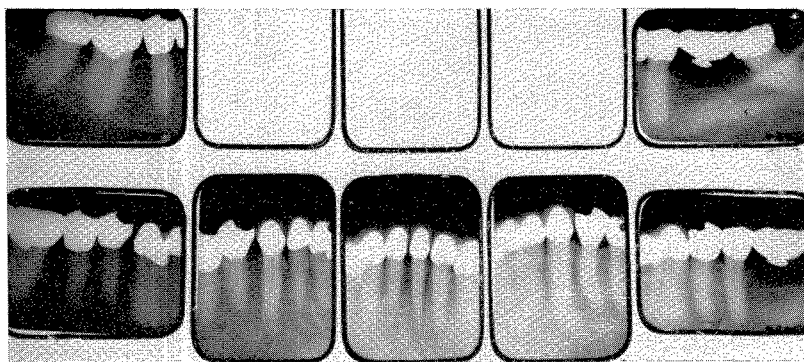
Roentgenograms of the completed lower work taken in August, 1962.
